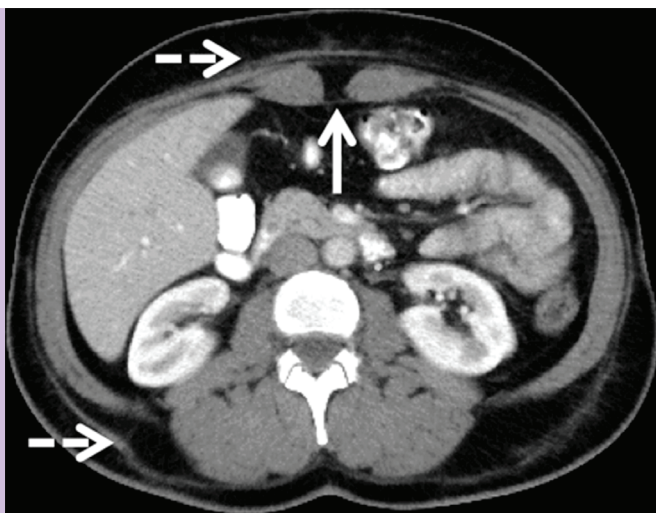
Transverse CT image of the abdomen shows linear subcutaneous fat stranding (dashed arrows) along the anterior and posterior abdominal wall, which represents the cannula tracks from liposuction. The characteristic midline inward protrusion of the rectus abdominis muscles (solid arrow) results from rectus muscle plication.
